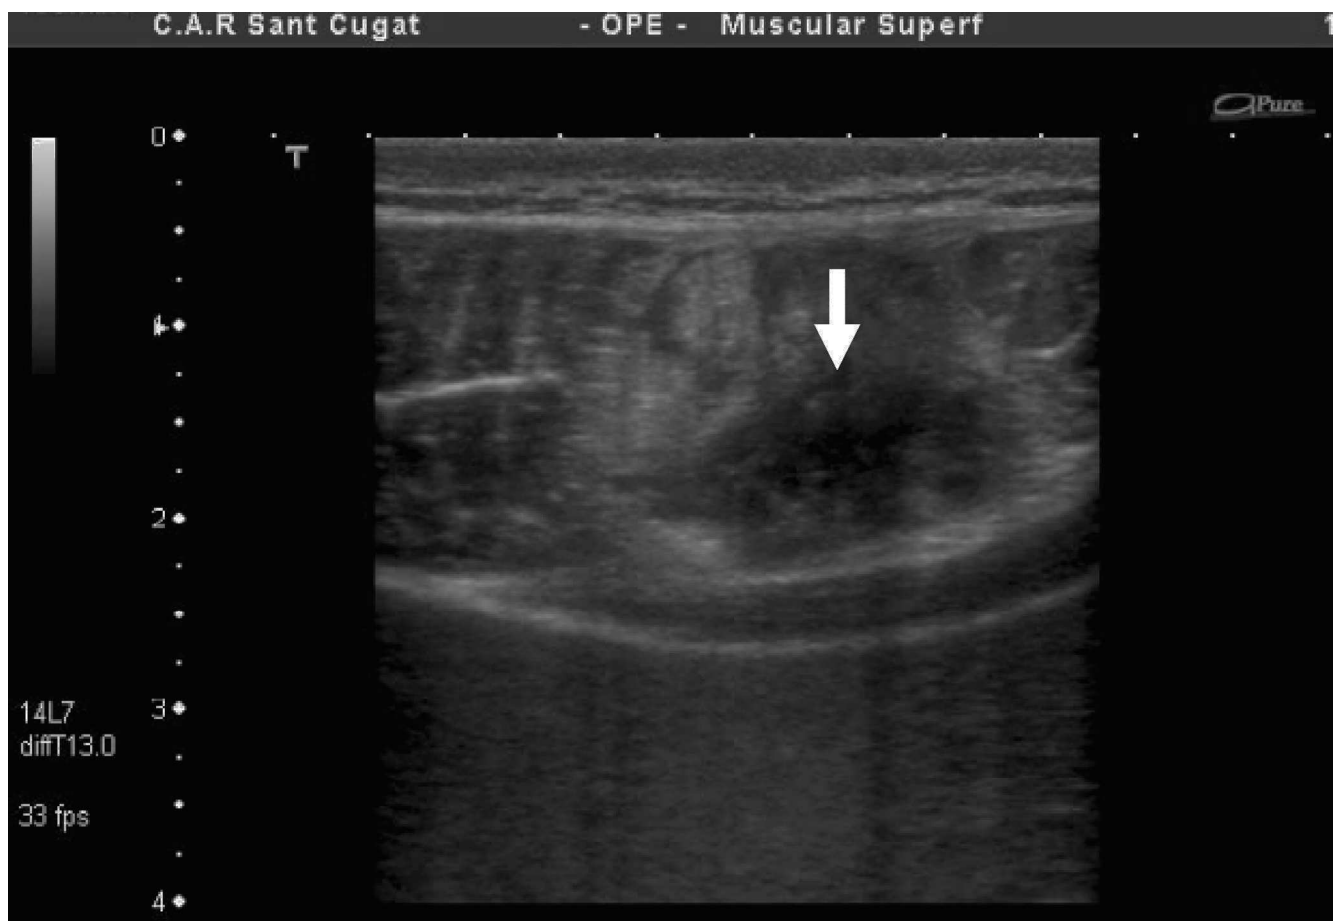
Transverse ultrasound image of the injury located in the area close to deep fascia of the right of the image.
